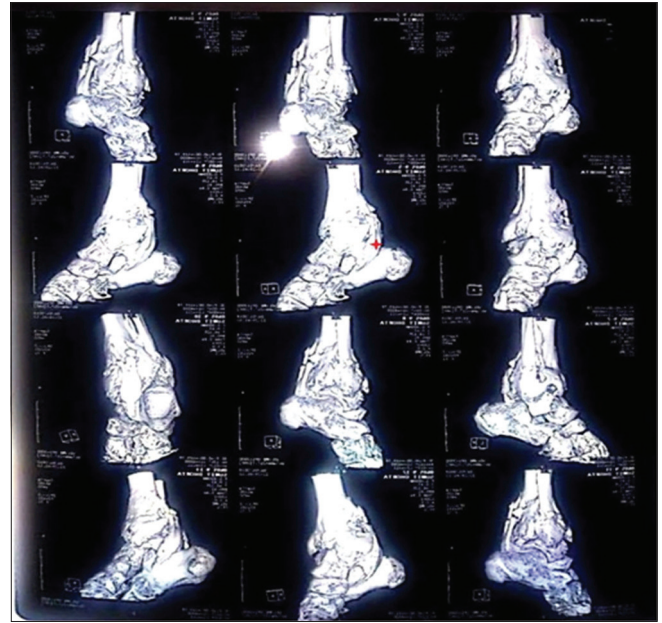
Pre-operative 3D CT reconstruction of the ankle joint.
